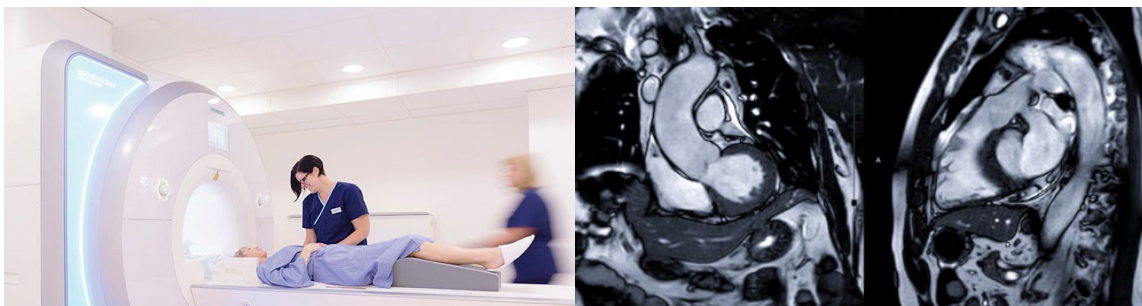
Magnetic resonance imaging (MRI) machine and scans of the heart (HCA, 2021; VH, 2022).
